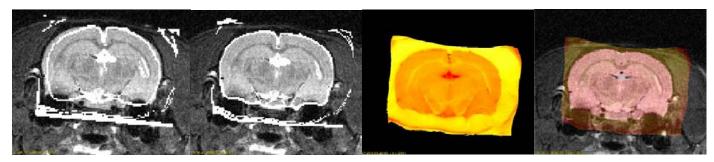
From left to right: 1) Photograph contours (white) overlaid on MRI after rigid registration, 2) after deformable registration, 3) Photograph after deformable registration, 4) Photograph overlaid on MR image.
